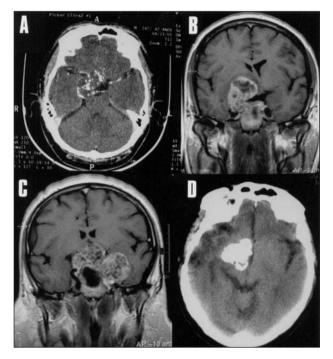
A (Patient 1), axial enhanced CT scan showing a mass in the cranial base extending from the right parasellar region to the clivus. B (Patient 1), coronal T1 weighted gadolinium-enhanced MRI scan revealing the same lesion; it was invading the right cavernous sinus and impinging on the hypothalamus. C (Patient 2), coronal T1 weighted gadolinium-enhanced MRI scan showing a left petroclival, heterogeneously enhancing lesion; it was invading the cavernous sinus. D (Patient 1), axial CT scan after radiotherapy showing calcification of the residual tumor.
